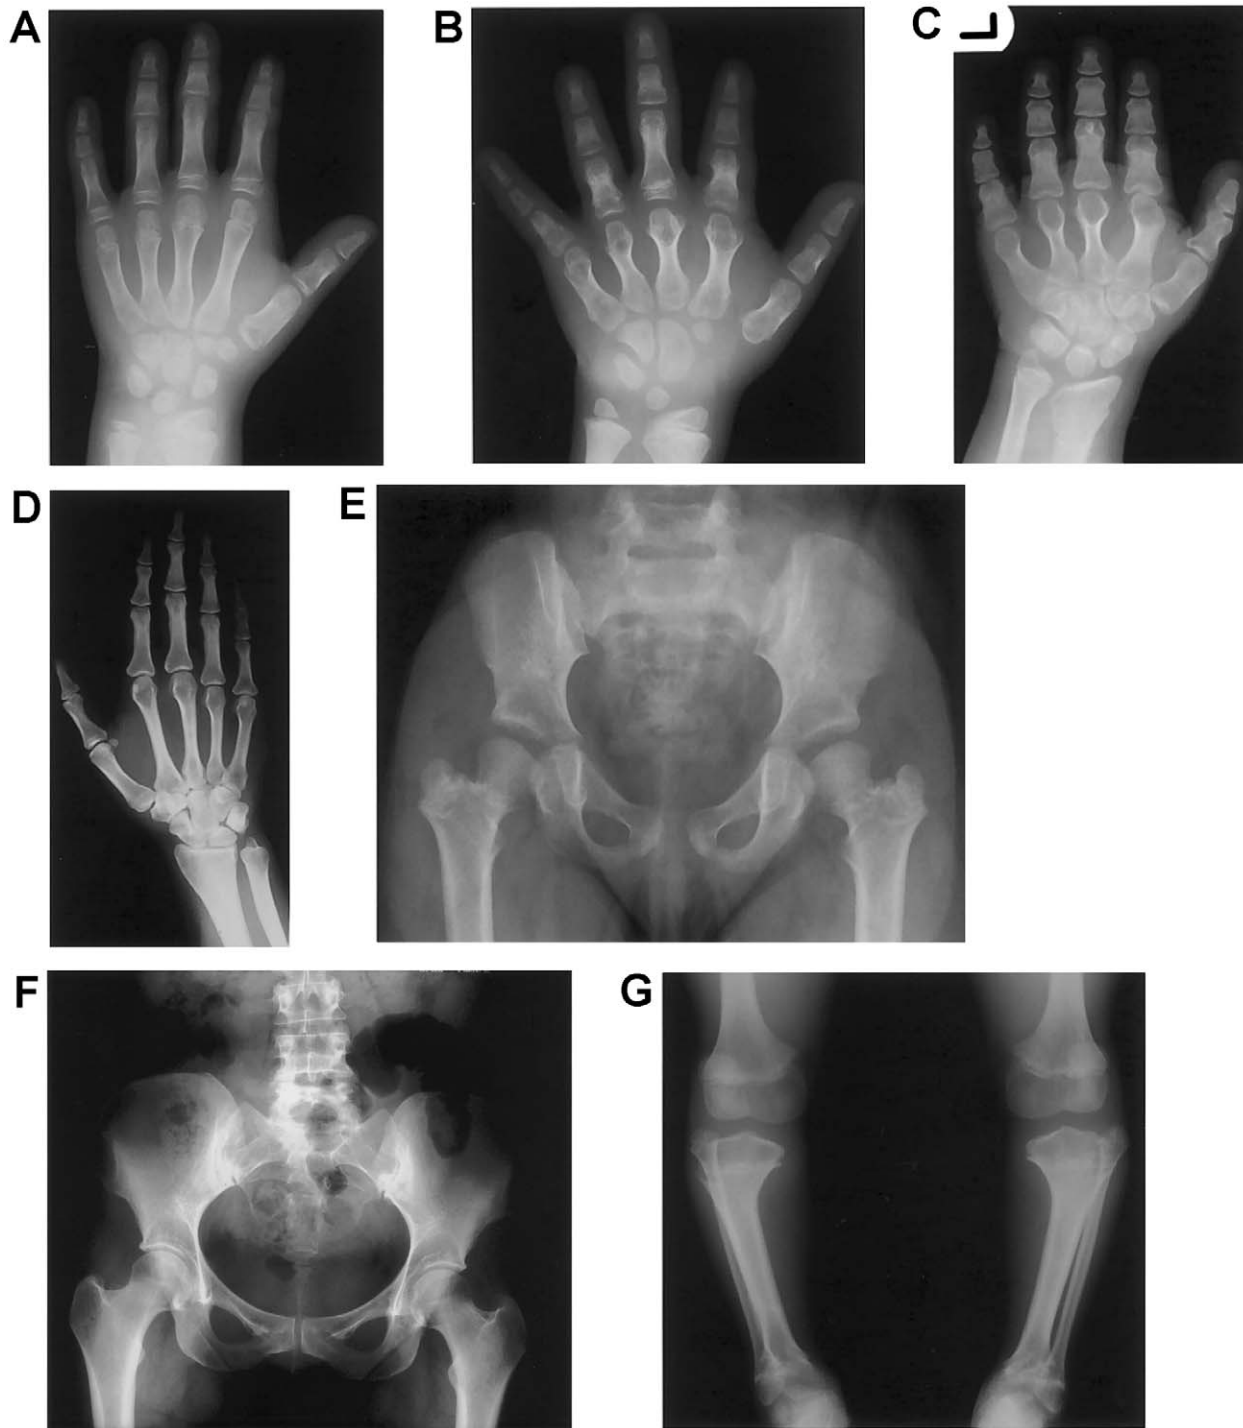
Most characteristic radiographic abnormalities in the affected individuals. *A–C*, Radiographs of the left hand. *A*, Cone-shaped epiphyses in the thumbs and the middle and distal phalanges of digits II–V of patient VII-4 at age 9.5 years. *B*, Shortening of the tubular bones more pronounced in patient IX-2 at age 11 years. Note the remnants of cone-shaped epiphyses and the fused “tear-drop” metacarpal epiphyses. *C*, Severe brachydactyly in patient IX-1 at age 14 years. Note complete epimetaphyseal fusion of metacarpals and phalanges. *D*, Radiograph of the right hand of parent VI-1, showing no obvious signs of BDA1. *E*, Radiograph of the pelvis in patient VII-4 at age 6 years, showing coxa vara with egg-shaped femoral head and very short femoral neck after epimetaphyseal fusion. *F*, Normal radiograph of the pelvis in parent VI-1, with no evidence of a premature fusion of the proximal femoral growth plate (normal femoral head and neck). *G*, Radiograph of the lower limbs in patient IX-2 at age 11 years. Varus deformity of the tibiae with proximal and distal premature epimetaphyseal fusion is most likely the result of cone-shaped epiphyses. Note the voluminous distal femoral epiphyses and the proximal overgrowth of the fibulae.
